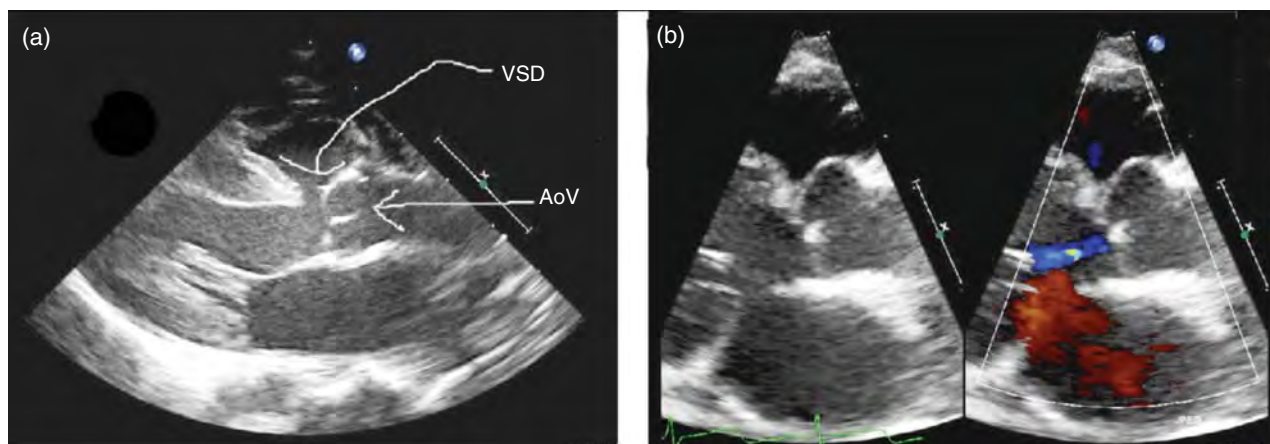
Conal septal defects: (a) parasternal long-axis image showing the relation to the aortic valve (AoV); (b) parasternal image without and with color showing closure of the defect by prolapsing AoV tissue and subsequent aortic insufficiency; (c) partial closure of the defect and small shunt; (d) parasternal short-axis image showing deficiency of the conal septum and aortic and pulmonary valvar continuity.
